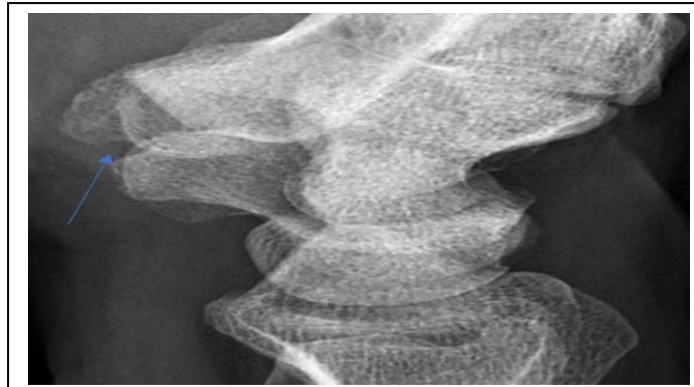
Lateral wrist plane x-ray with prominent scaphoid tubercle (Blue arrow), otherwise unremarkable.
